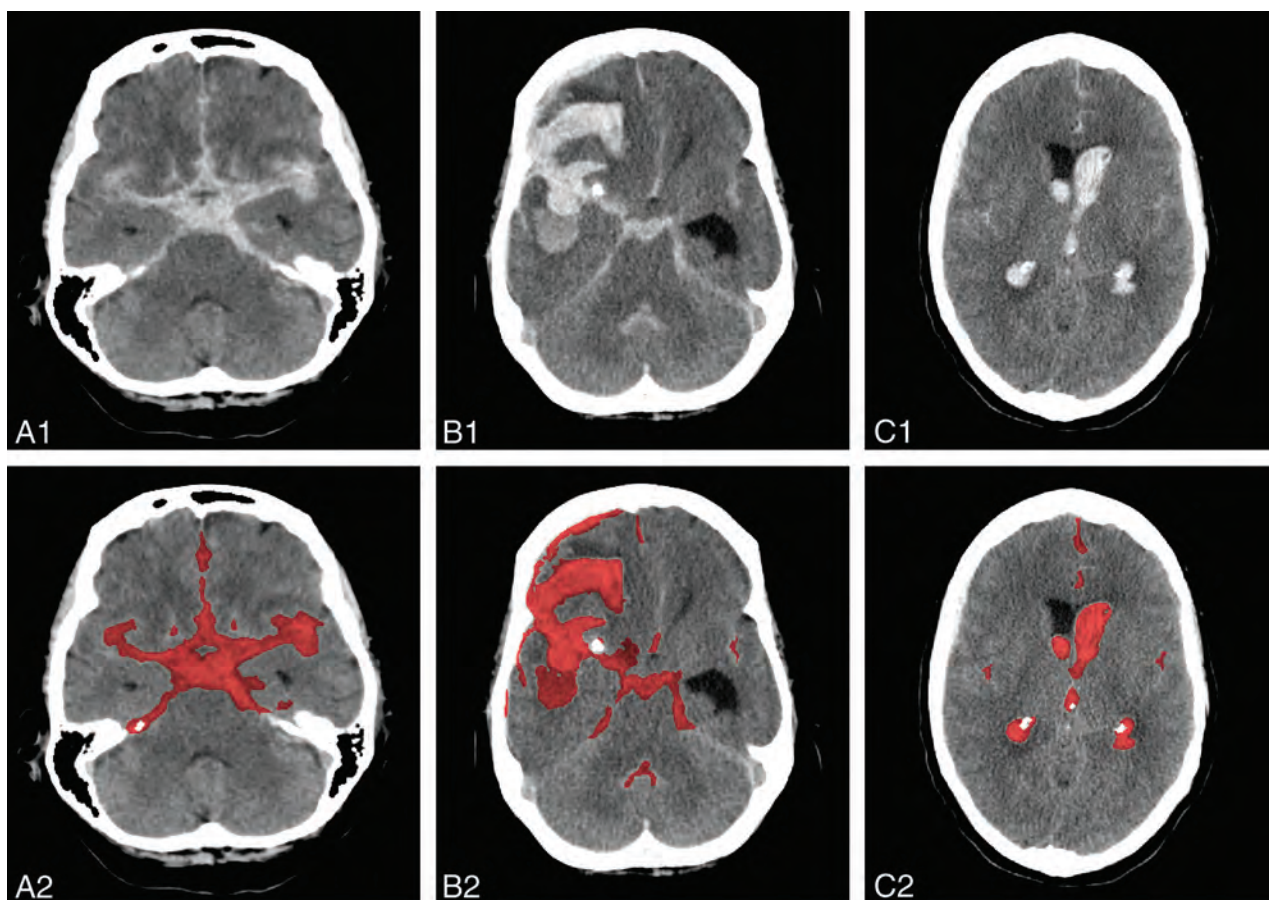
Examples of SAH bleeding patterns on CT (upper), with corresponding segmentations in red as provided by the automatic quantification method (lower).¹⁰ A, SAH with blood in both Sylvian fissures. B, SAH with the presence of IPH. C, SAH with the presence of IVH.
